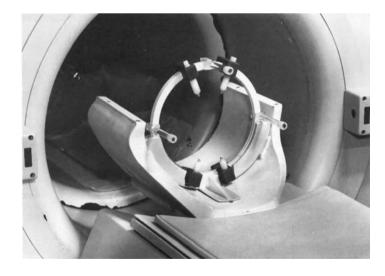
MRI-stereotaxy ring with ringholder and special head coil
